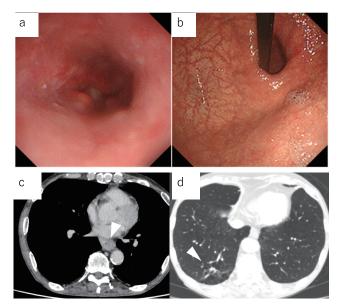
Endoscopic and CT findings after chemotherapy a) Thoracic computed tomography: Wall thickness of the lower thoracic esophagus (arrowhead) decreased.
